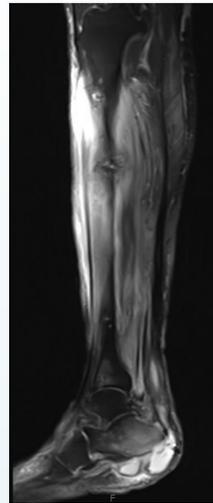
T2-weighted MRI images with reported bone marrow edema in the calcaneus and proximal tibia and enhanced fluid collection initially interpreted as abscess formation and acute osteomyelitis. Bone biopsies of each area in question were negative for osteomyelitis, no growth on deep wound culture.
